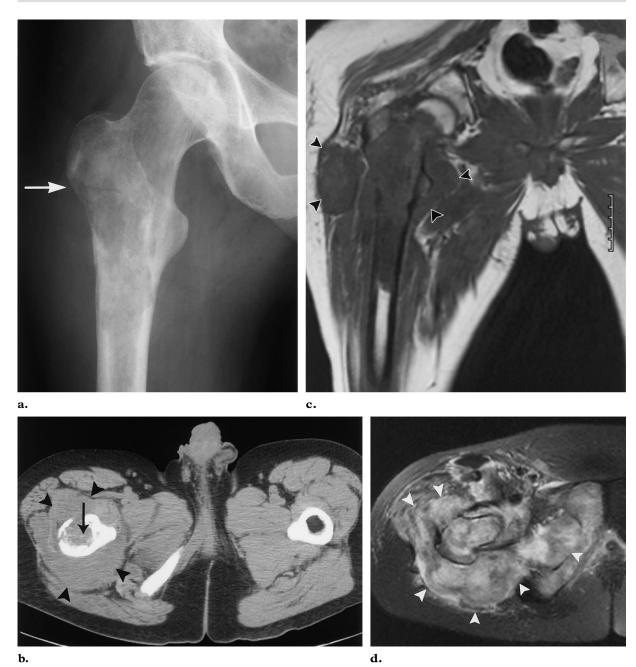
(a) Radiograph demonstrates a mixed lytic and sclerotic lesion with a permeative, aggressive, nonspecific pattern. A subtle intertrochanteric and subtrochanteric fracture is also seen (arrow). (b) CT scan reveals intraosseous chondroid matrix (arrow) and an unmineralized soft-tissue mass (arrowheads). (c, d) Coronal T1weighted (c) and axial T2-weighted (d) MR images more clearly show the size and extent of the large unmineralized soft-tissue mass (arrowheads), which represents the dedifferentiated component of a bimorphic cartilage tumor.
